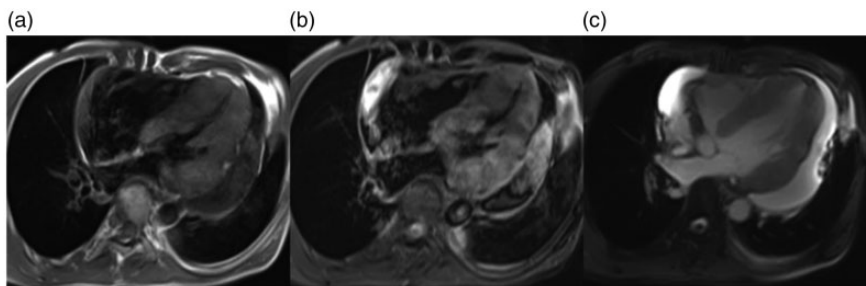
(a) T1-weighted magnetic resonance image showed a nodular left ventricular wall with a uniform signal. (b) T2 fat-suppression magnetic resonance image showed no clear myocardial edema. (c) Cine image showed normal systolic function with an ejection fraction of 51% and large volume.
